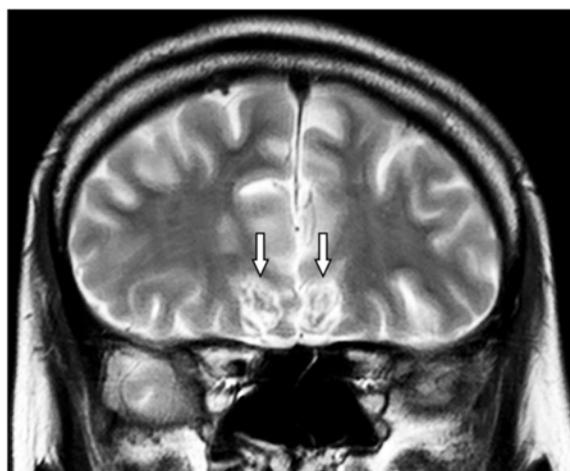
Coronal MRI of the brain following subcaudate tractotomy showing lesions at the substantia innominata (arrows).
